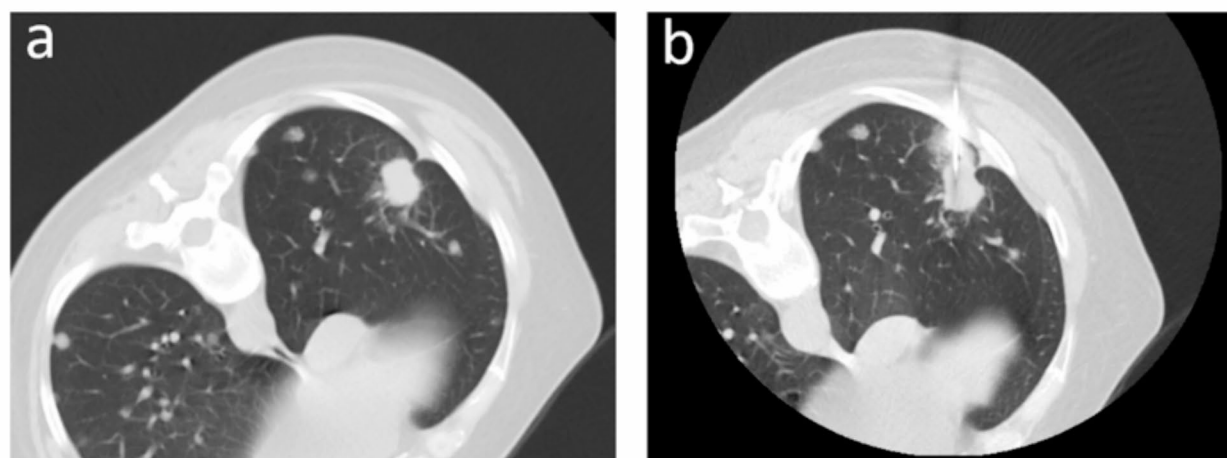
A PTNB procedure on a nodule with PTS in a 41-year-old female patient. (a) A chest CT image shows multiple nodules in both lungs and the bigger one with PTS is in right lower lobe. (b) Our puncture path avoided the tags and the pleura affected by the PTS. There was no pneumothorax in Postoperative CT
